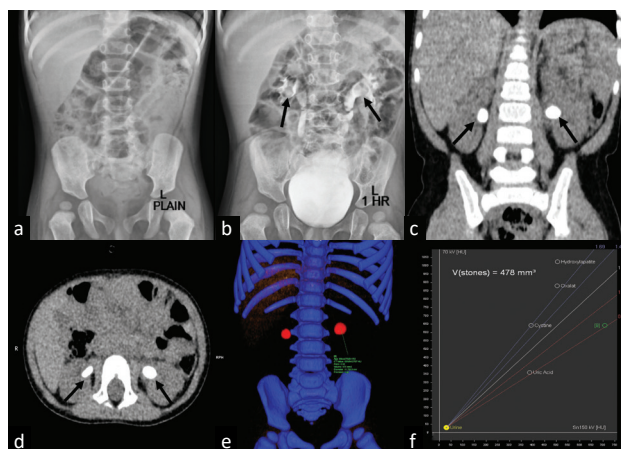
Plain radiograph (a) shows no radiopaque calculi in the renal fossae on either side, while post-contrast injection 1-h spot (b) shows two radiolucent filling defects in the bilateral renal pelvis (black arrows) with mild hydronephrosis. Coronal (c) and axial (d) multiplanar reformatted images of dual-energy computed tomography (DECT) scan show bilateral renal calculi (black arrows in c and d) with mild hydronephrosis. Color overlay image (e) of DECT scan shows bilateral renal calculi, which are color-coded red. On dual-energy radiograph evaluation (f), left renal calculus (region of interest shown in e) is seen to have a uric acid composition (green circle in f).
